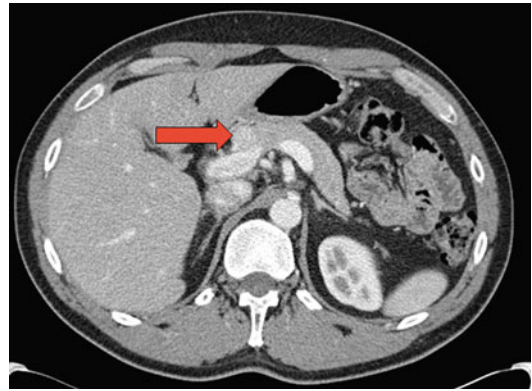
Contrast-enhanced computed tomography of the abdomen including triphasic imaging through the pancreas of a 38-year-old male with hyperinsulinemic hypoglycemia. A subtle, rounded, 1.8-cm nodule in the neck of the pancreas slightly enhances on the late arterial phase, concerning for an insulinoma
